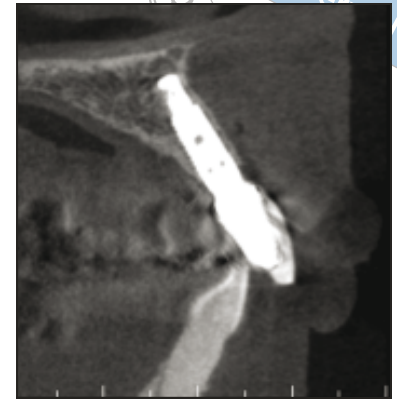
CBCT scan taken 1 year after loading.
